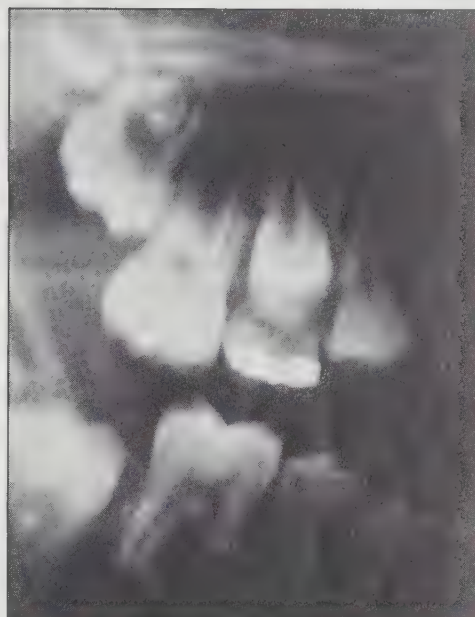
A closer view of the same radiograph.
